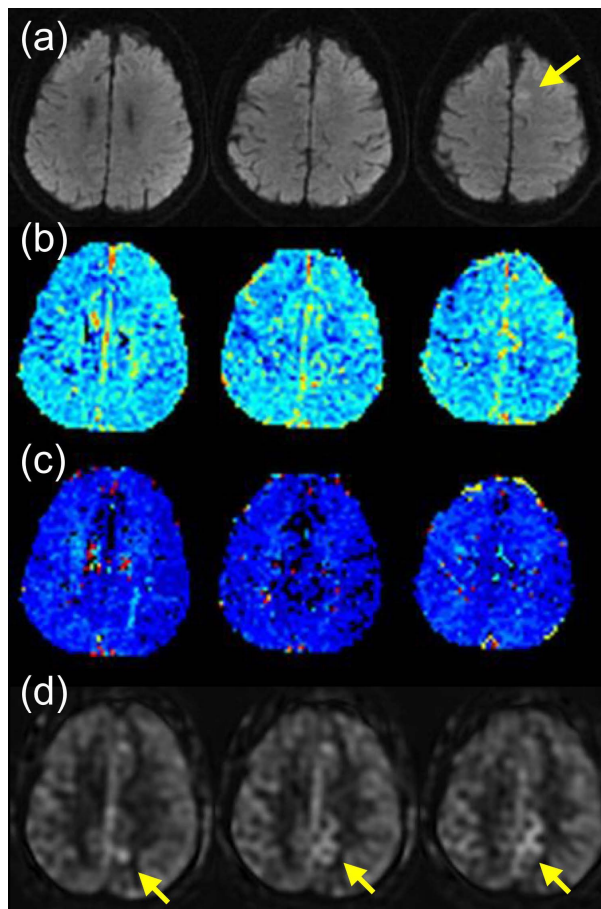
71 year-old woman with transient right leg weakness (ABCD² score 4). (a) DWI shows a subtle lesion in the left ACA territory. (b) MTT and (c) Tmax maps are normal. (d) ASL demonstrates serpiginous high signal near the diffusion abnormality (arrows), likely representing delayed arterial arrival time. ASL may increase the yield of identifying vascular disturbances in patients with TIA.
